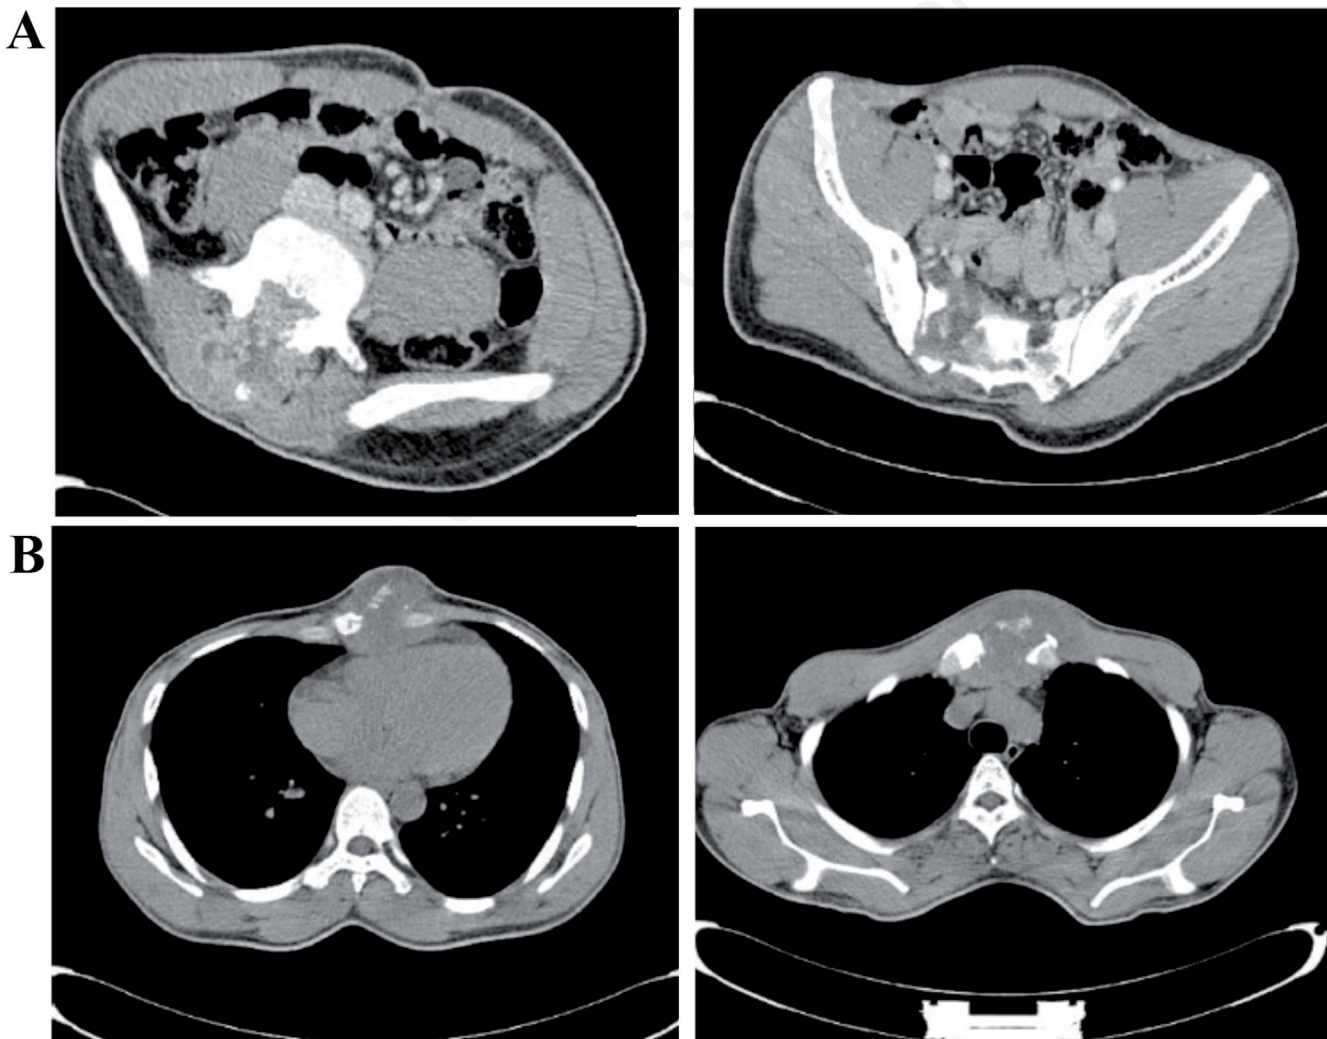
CT scan showing a mass involving the spinal cord (L4-L5/L5-S1) and the sacral bone (A) and a voluminous mass involving the sternum (B).
